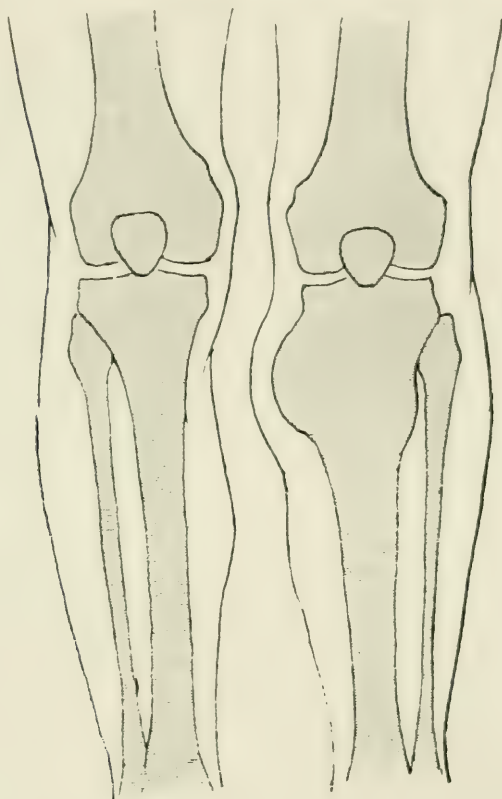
Osteo-sarcoma of the tibia (from a radiograph). Diagnosis with osteo-myelitis. In osteo-sarcoma the bone is like a club, it is fusiform in osteo-myelitis (see fig. 1030). In osteo-sarcoma the onset is insidious, there is scarcely ever fever, development less rapid.
